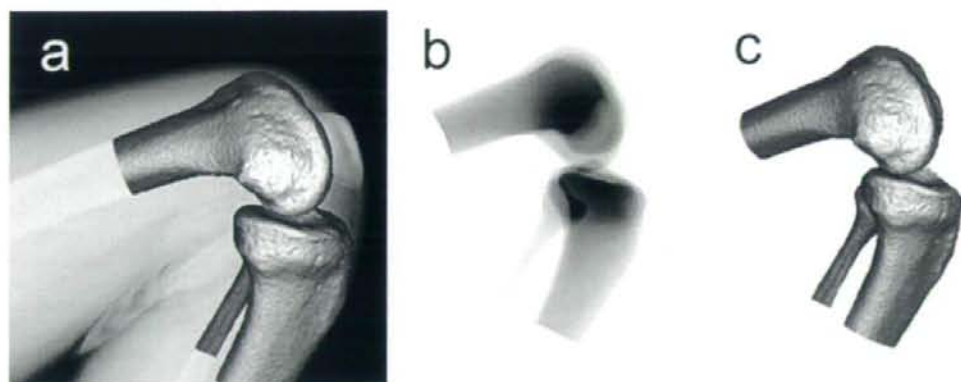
Matching of bone model to X-ray image (a), synthetic image generated using ray tracing (b), and matching of bone model to synthetic image (c).
